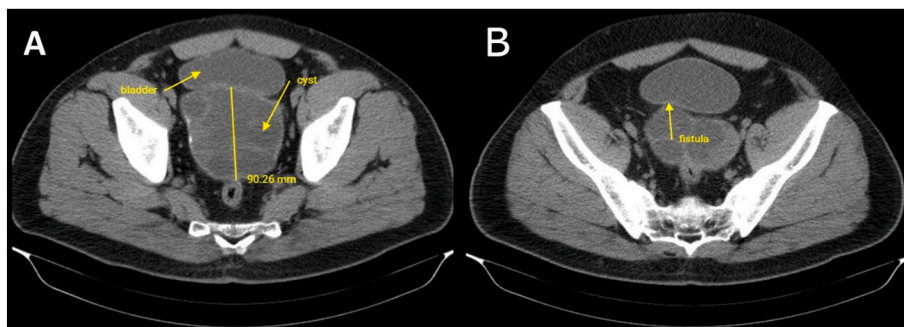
Pelvic CT. A. Lobulated cystic lesion B. Connection between cyst and bladder.
